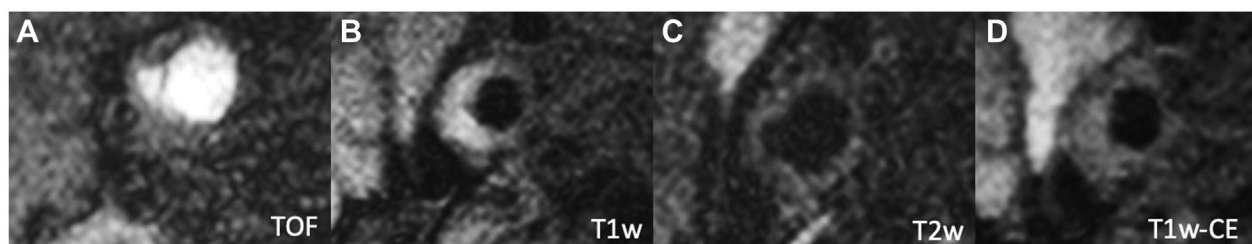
Example of intraplaque hemorrhage (IPH) in the right internal carotid artery of a 67-year-old man with an ipsilateral ischemic stroke. (A-D) Nonstenosing carotid atherosclerotic plaque with ulceration within the plaque (white arrow in A and C) and bright signal in T1-weighted images (B) indicative of IPH, in particular, early subacute as highlight in T2-weighted images (C). TOF, time of flight.
